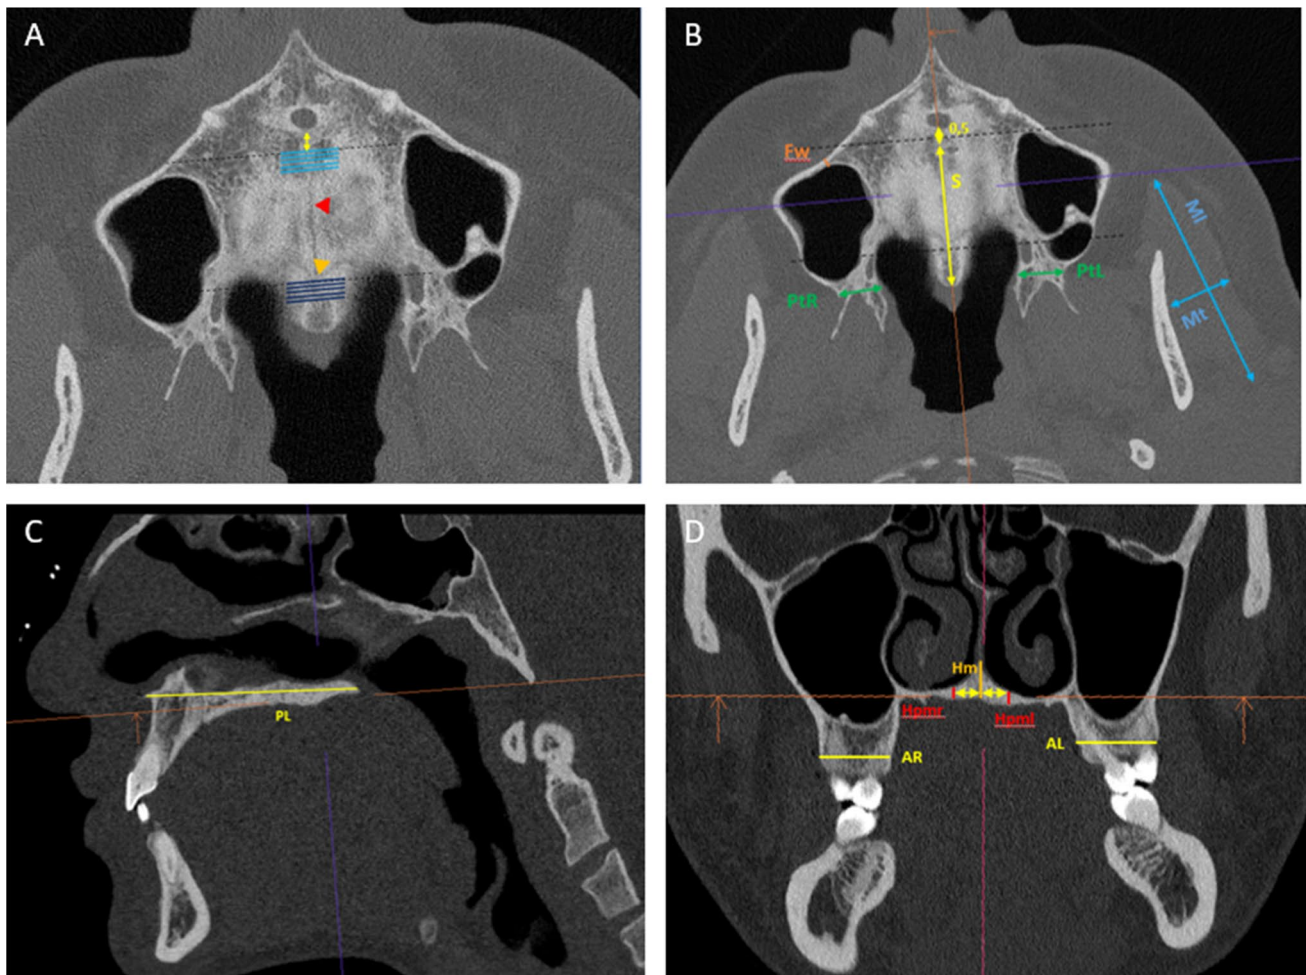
Measurements performed in the axial (A, B), sagittal (C), and coronal slices (D) of the CT datasets. A: Anterior (light blue lines) and posterior palatal thickness (dark blue lines) were measured in 5 consecutive slices in the maxillary and palatine bone. The mid-palatal suture (red arrowhead), as well as the transverse palatine suture (orange arrowhead), are depicted. B: Further measurements conducted within the axial slices are the thickness of the maxillary
